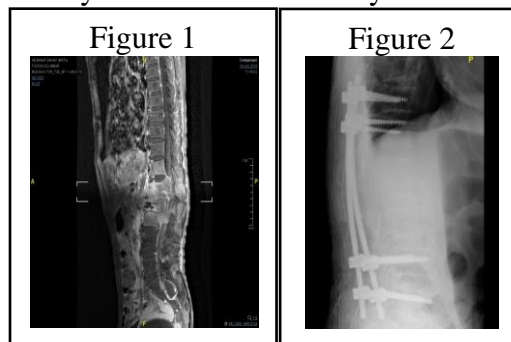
Mid-sagittal T1 weighted MRI showing vertebral destruction from L1-L3 vertebrae and severely compressed spinal cord at the level T12/L1/L2
